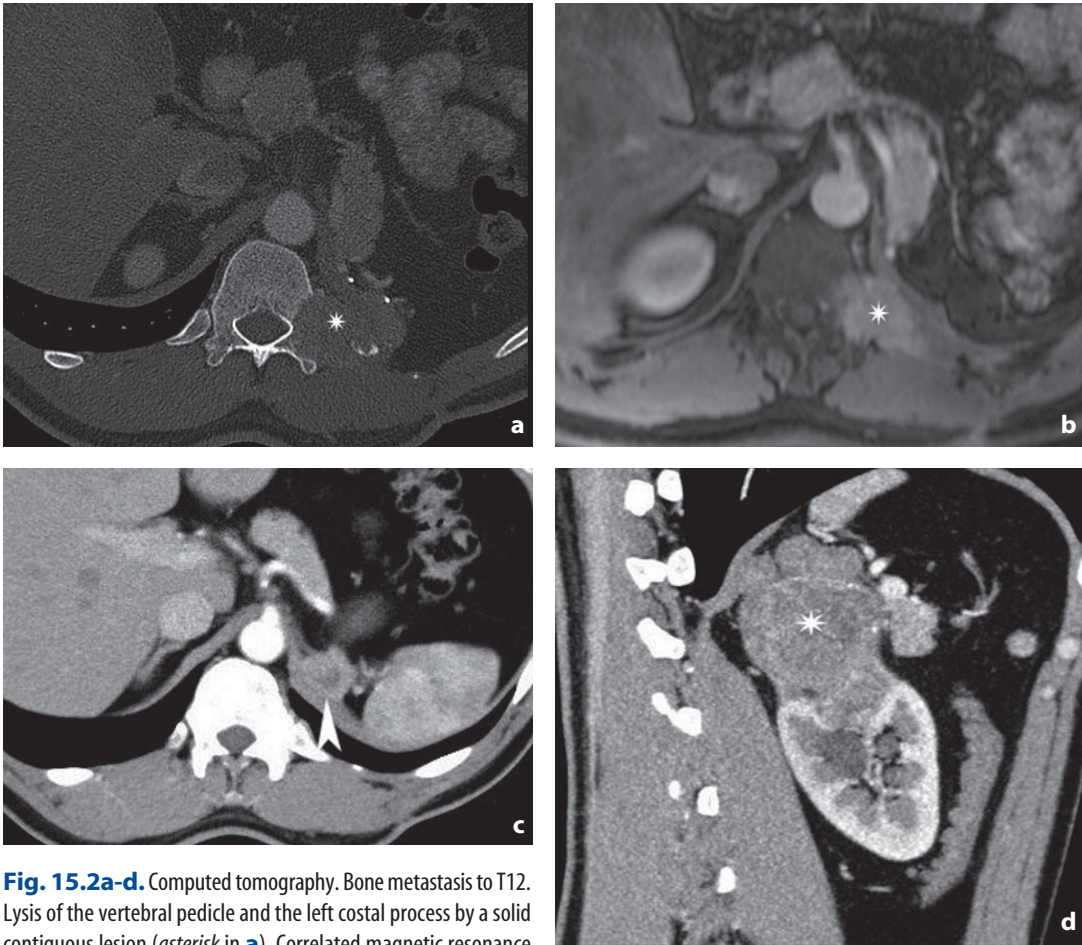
Computed tomography. Bone metastasis to T12. Lysis of the vertebral pedicle and the left costal process by a solid contiguous lesion (*asterisk in a*). Correlated magnetic resonance image (*b*). Patient history: previous resection of local-regional recurrence (*arrowhead in c*) of a T3a renal cell carcinoma (*asterisk in d*)
